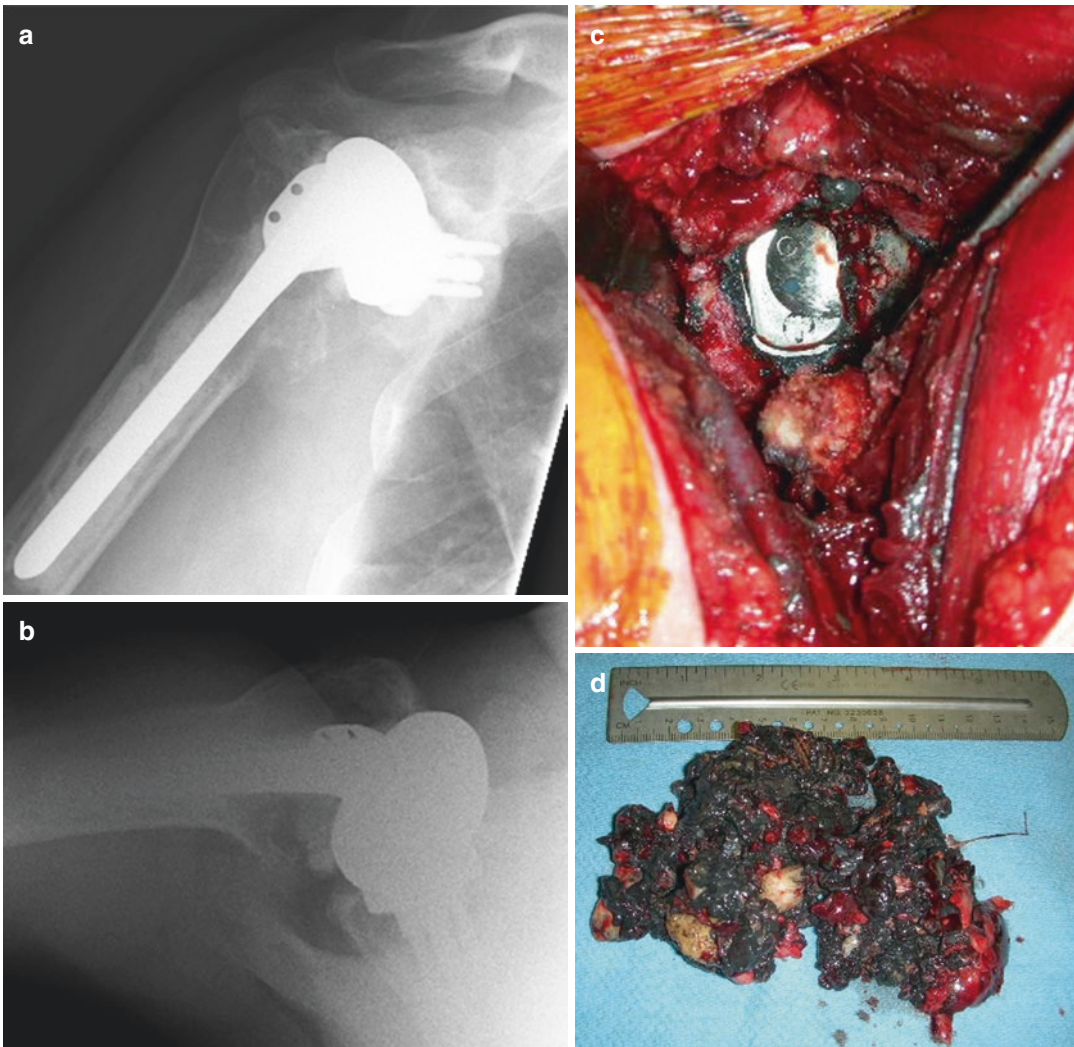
Failed metal-backed glenoid. AP (a) and lateral (b) radiographs demonstrating a failed glenoid component. Intraoperative photo demonstrating metal debris
